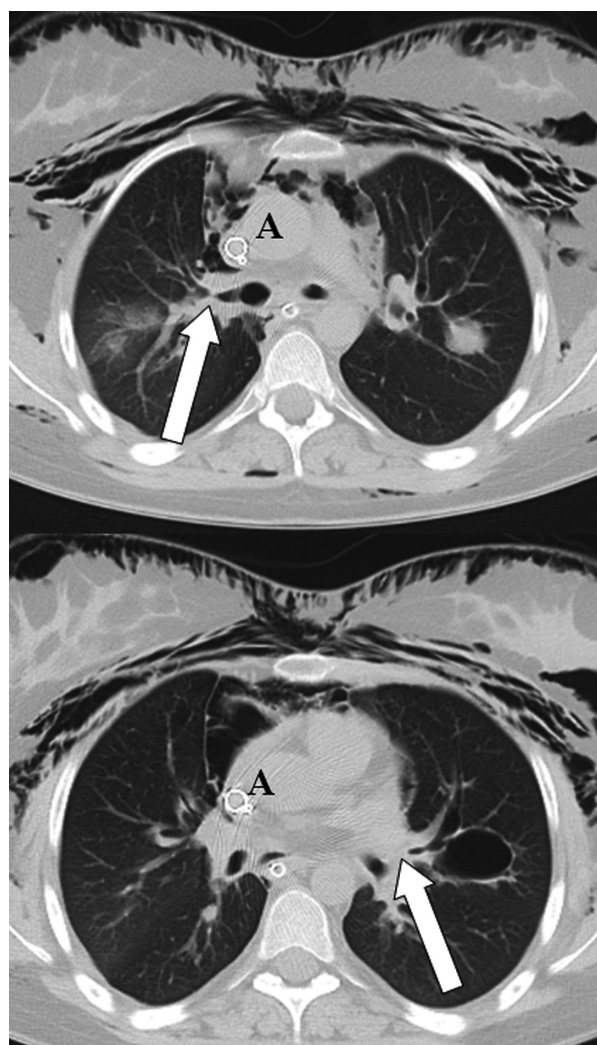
Two horizontal chest CT scan frames from the day of arrival to our ECMO ICU. The arrows indicate obliterations of the major airways. (A) indicates the draining ECMO cannula. The smaller cannula attached is the line of the Port-à-cath. The subcutaneous emphysema can be seen at top, but soft tissue emphysema has also dissected its way in the pectoral muscles.
